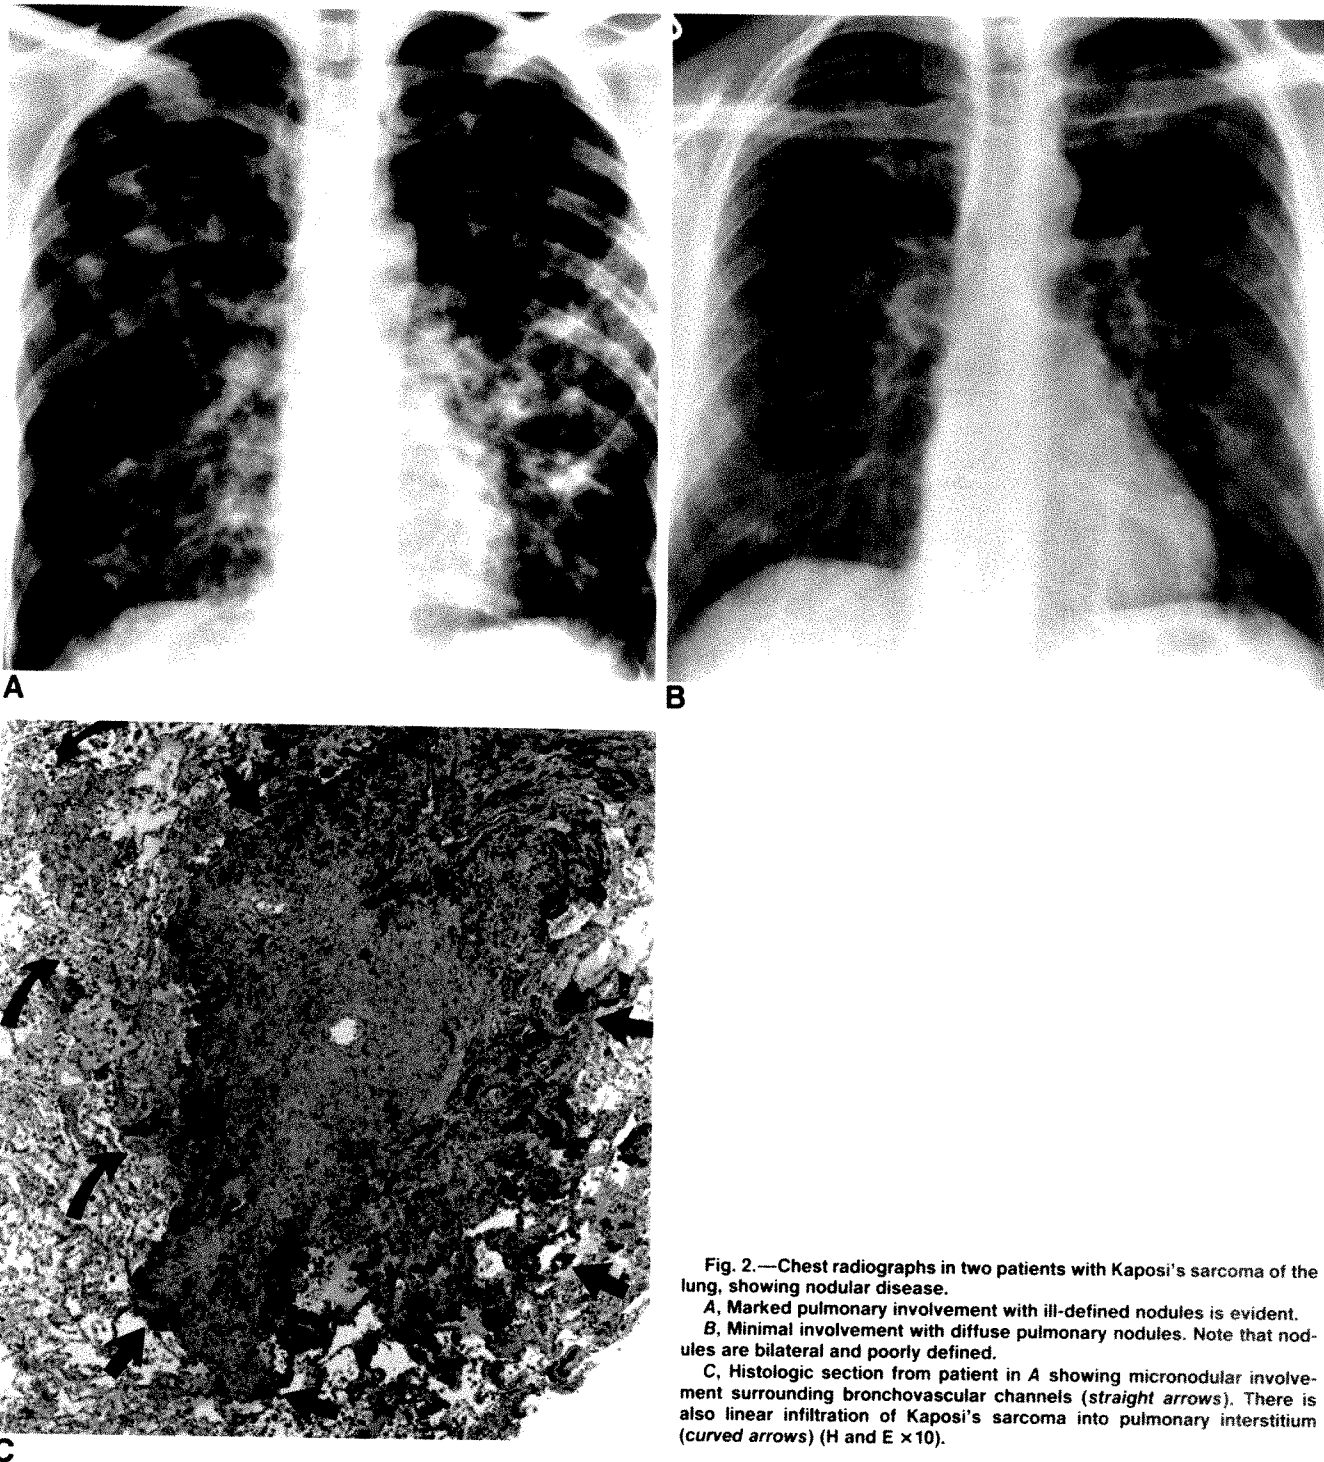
Chest radiographs in two patients with Kaposi's sarcoma of the lung, showing nodular disease.
